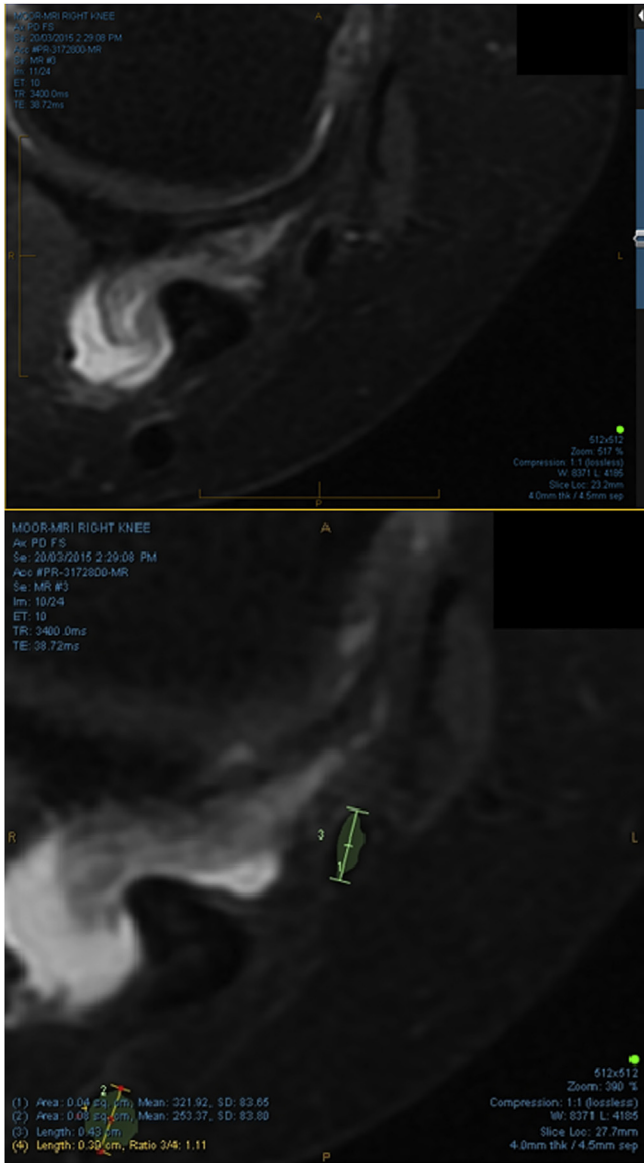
Measurements performed on the digital MR images using IntelViewer system, before (top) and after (bottom) the region-of-Interest and diameter measurement tools were applied manually to the tendon regions of the image.
